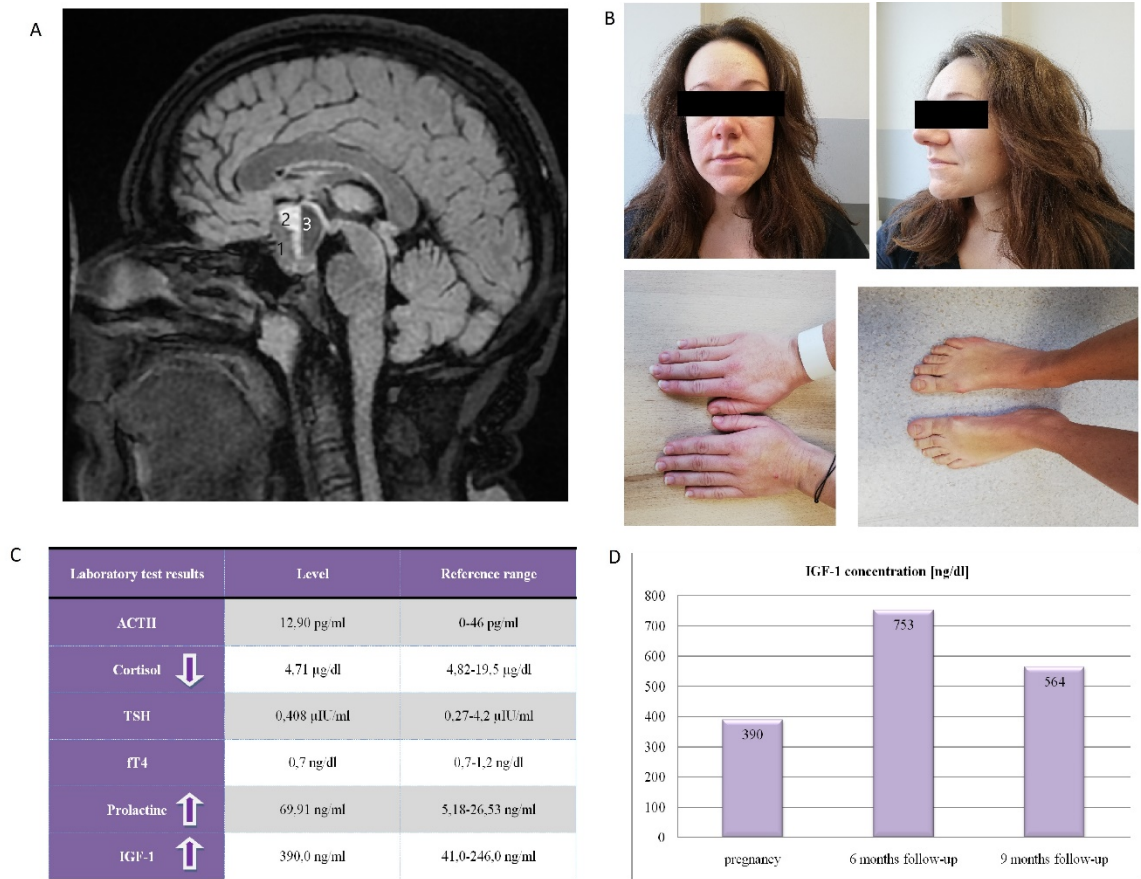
A. Head magnetic resonance imaging (MRI) — macroadenoma: 1 — solid part of the tumor, 2 — the area of bleeding to the tumor, 3 — cystoid part of the tumor; B. Pictures of the patient; C. Laboratory test results; D. Insulin growth factor 1 (IGF-1) concentration
